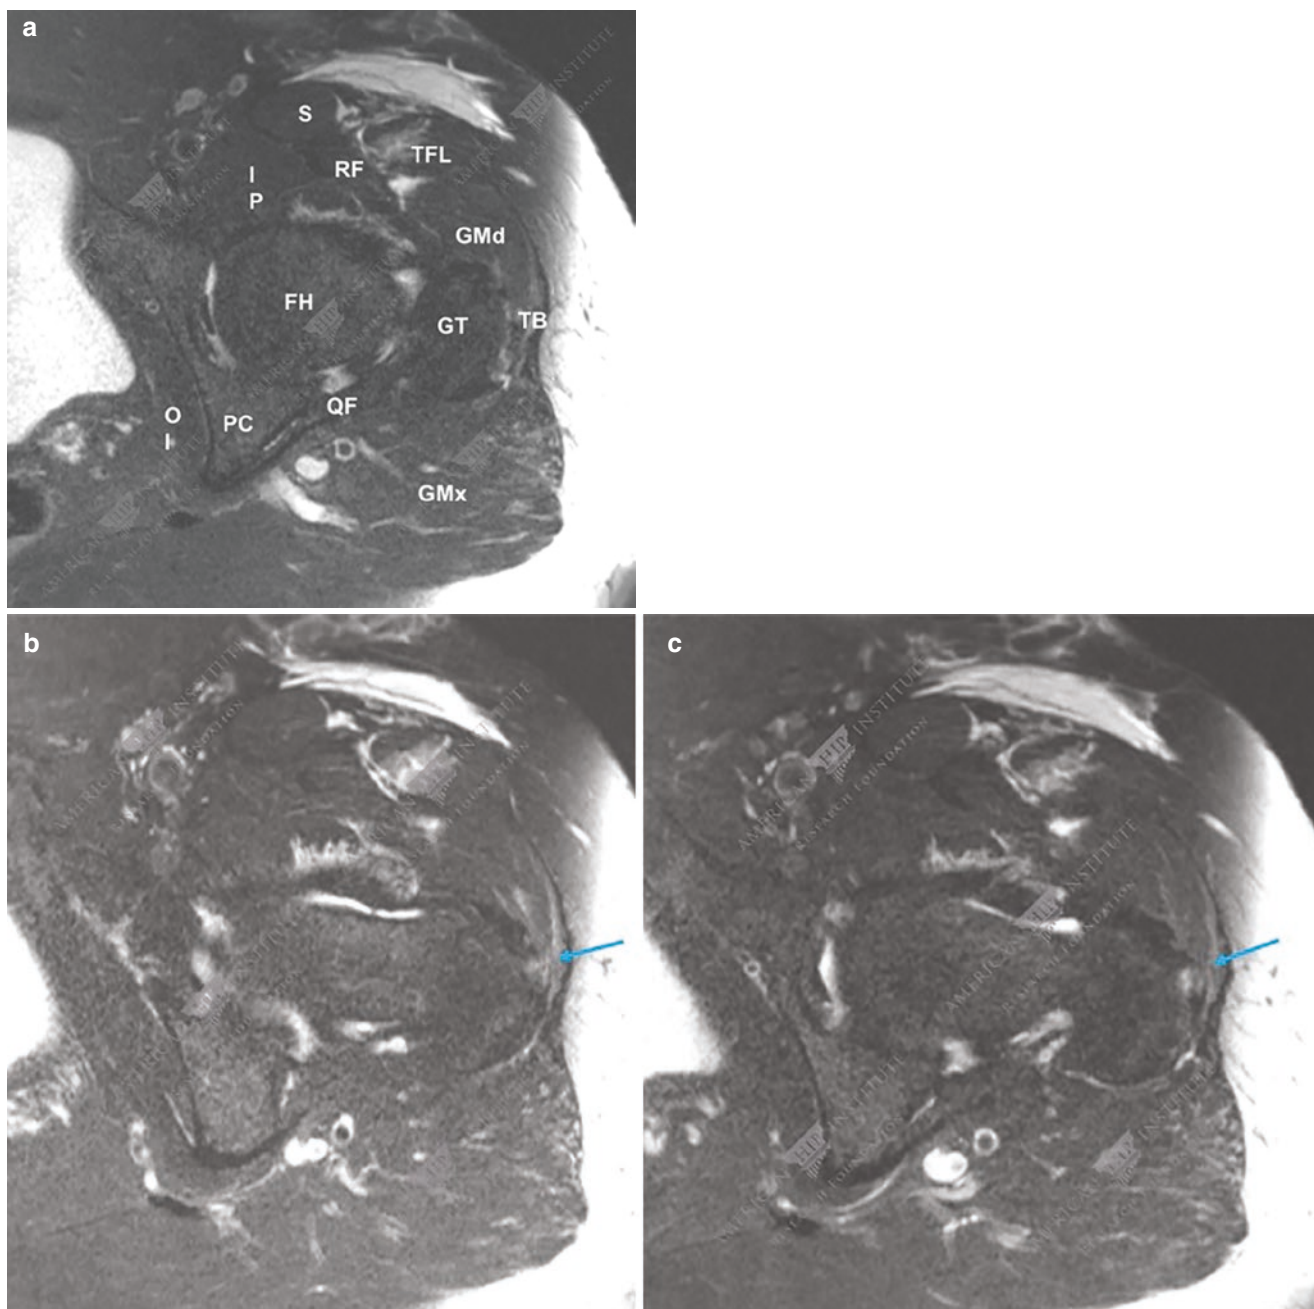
(a) Axial fat-saturated T2-weighted image. Surrounding anatomic structures in clockwise direction: *S* sartorius, *IP* iliopsoas, *FH* femoral head, *OI* obturator internus, *PC* posterior column, *QF* quadratus femoris, *GMx* gluteus maximus, *TB* trochanteric bursa, *GT* greater
